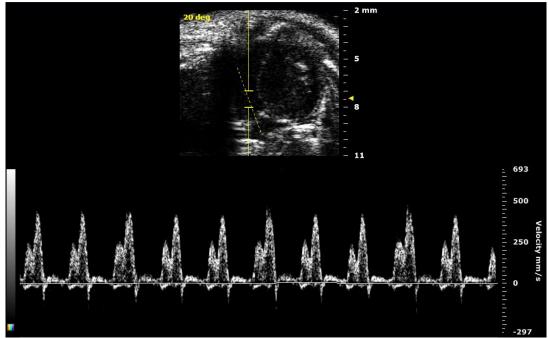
PW Doppler Mode waveform of Tricuspid flow in the apical four chamber view.
